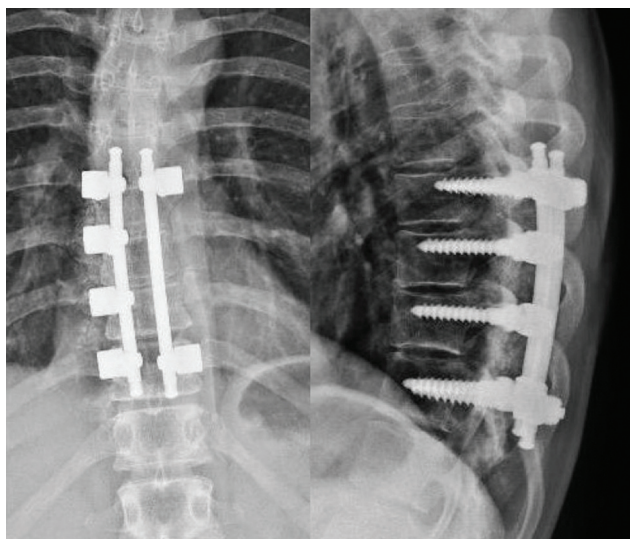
Posterolateral and lateral radiographs of the thoracic spine at the end of the procedure, showing adequate position and alignment of the pedicle screws.
